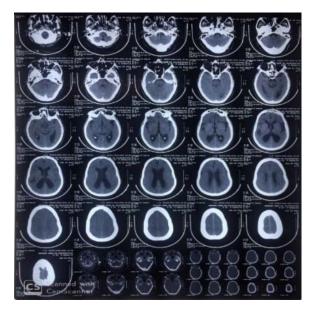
CT-scan image of patient no. 1
